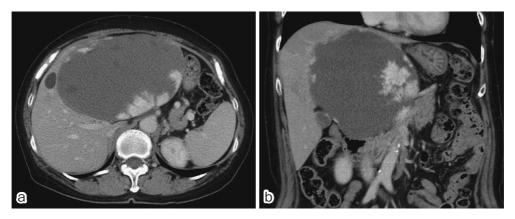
A computed tomographic (CT) scan, showing homogenous low-density areas, 15 cm in diameter, in the left lobe.
